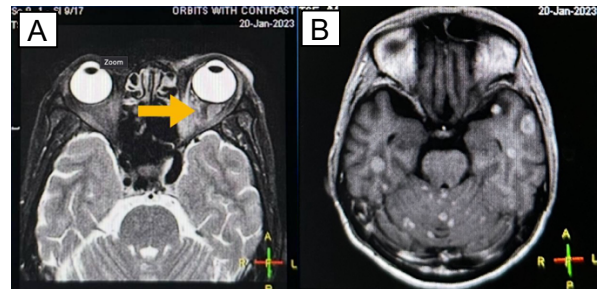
(A) Axial T2-weighted MRI demonstrating peripherally enhancing soft tissue signals in the left intraconal retrobulbar space, with lateral displacement of the left optic nerve. (B) Axial T1-weighted MRI showing numerous small enhancing nodules with peripheral enhancement in the supratentorial and infratentorial brain parenchyma, ranging from 2 mm to 12 mm in size.
